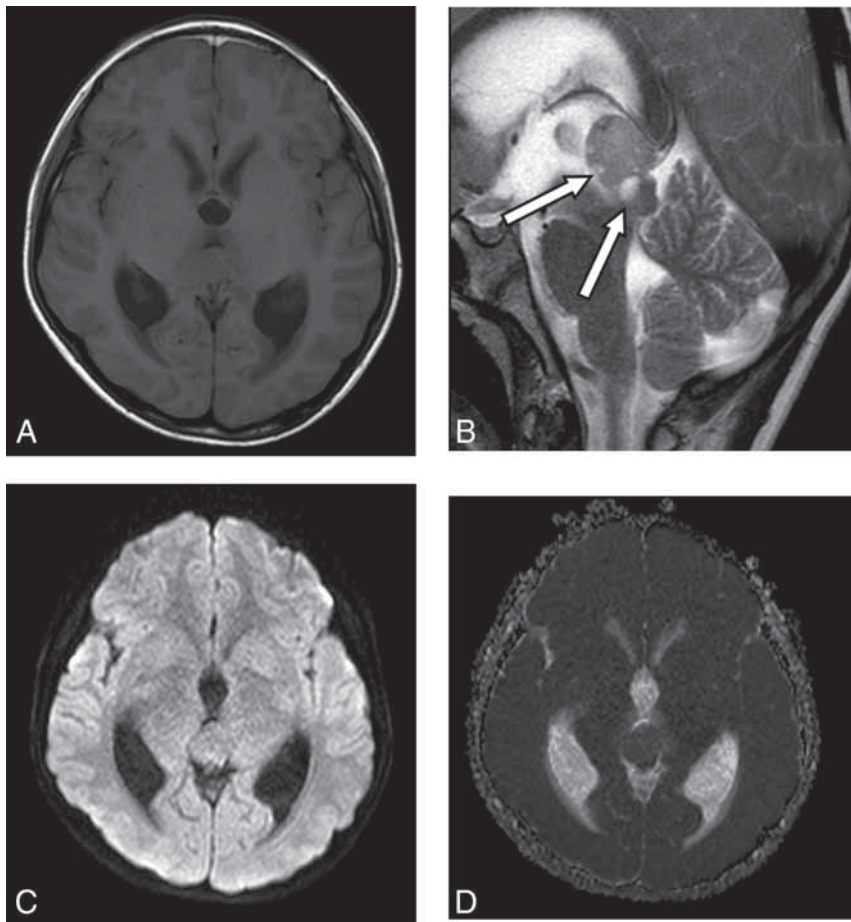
An 11-year-old boy with a pineal region YST. *A*, MR image shows the tumor located in the pineal region with a slightly low signal associated with supratentorial dilation of the ventricle. *B*, The T2 sequence shows multiple, fine cysts with hypersignal (arrows). *C* and *D*, The DWI sequence and ADC map show that the tumor signal is the same as that of the cerebral cortex.
